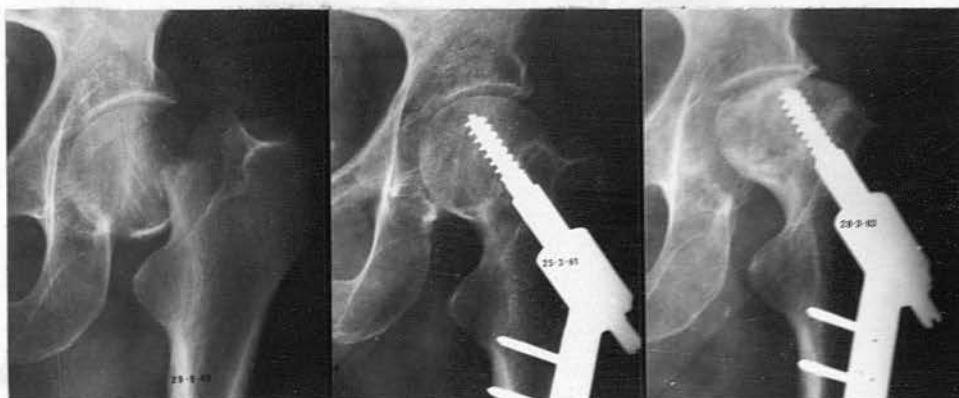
(a), (b), (c) - Transcervical fracture of the left femoral neck with internal fixation. Radiographic evidence of bone necrosis developing in head of left femur between 25.3.61 and 28.3.63.
